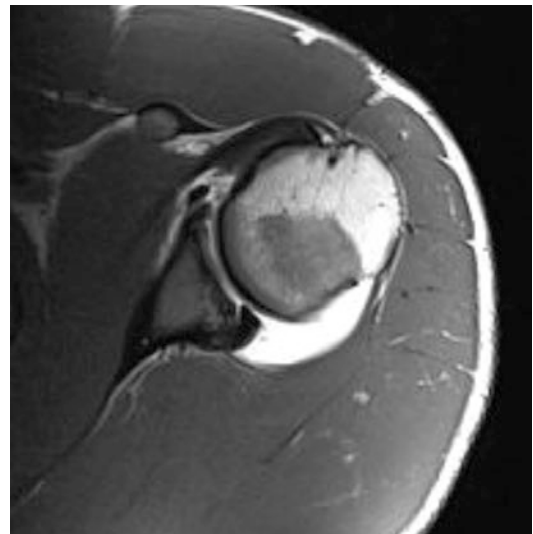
MRI (axial) image showing a retroverted glenoid with chronic posterior chronic labral tear. (Courtesy Lennard Funk, MD)
